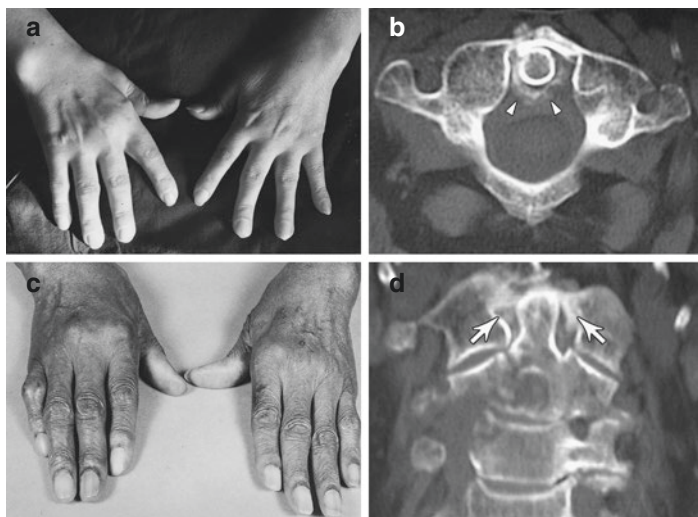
Clinical presentations of CPPD. (a) Pseudo-rheumatoid arthritis with ulnar deviation, interosseous muscle atrophy, and metacarpophalangeal and wrist involvement. (b) Pseudo-arthritis. (c, d) Crowned dens syndrome with calcification around the dens. Axial (c) and reformatted coronal (d) CT scan images at C1–C2 level with calcification of transverse ligament (arrowheads) and surrounding odontoid process (arrows)
